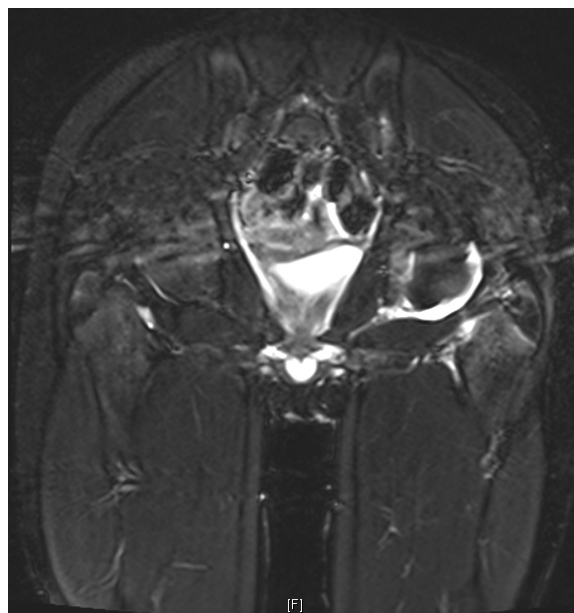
Contrast-enhanced magnetic resonance imaging showed joint effusion and thickening of the synovial membrane of left hip joint and spared the right side
